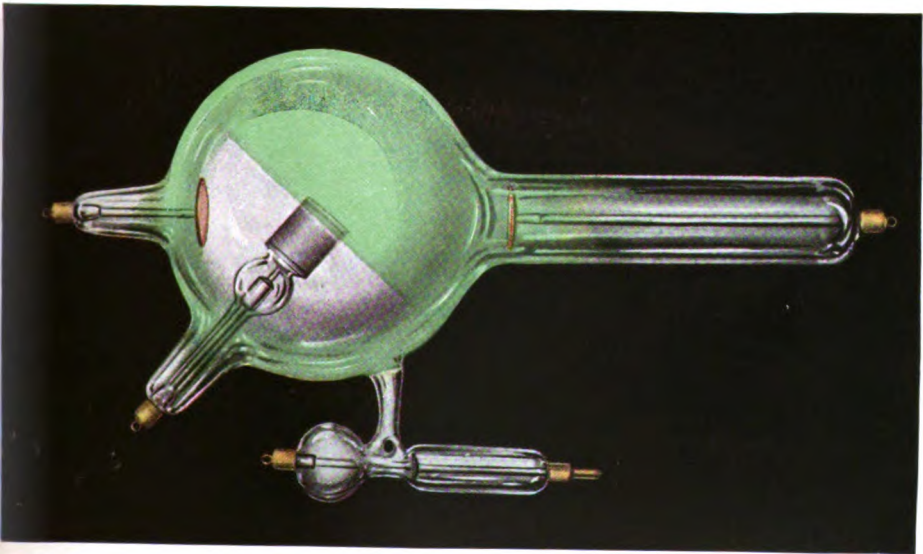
X-ray tube in operation. Almost ideal condition.
